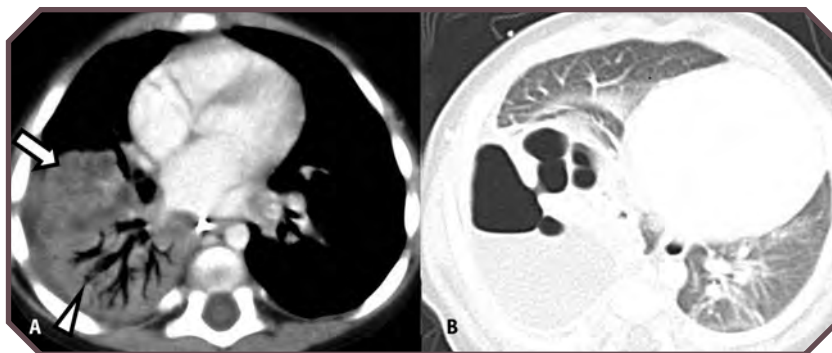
Complicated pneumonia in a 6-year-old child. A. Axial contrast-enhanced computed tomographic (CT) image demonstrates right lower lobe airspace attenuation. Note the region of patchy, poor perfusion (arrow) anterior to the region of extensive air bronchograms (arrowhead). B. Follow-up axial CT image obtained 13 days later demonstrates right lower lobe cystic necrosis. A chest radiograph obtained 2 years later, at 8 years of age, demonstrated normal findings (not shown).
